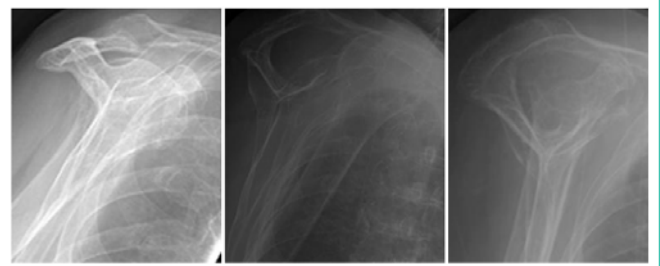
The X-rays above correspond to the lateral views of Figures 1A-1C.
